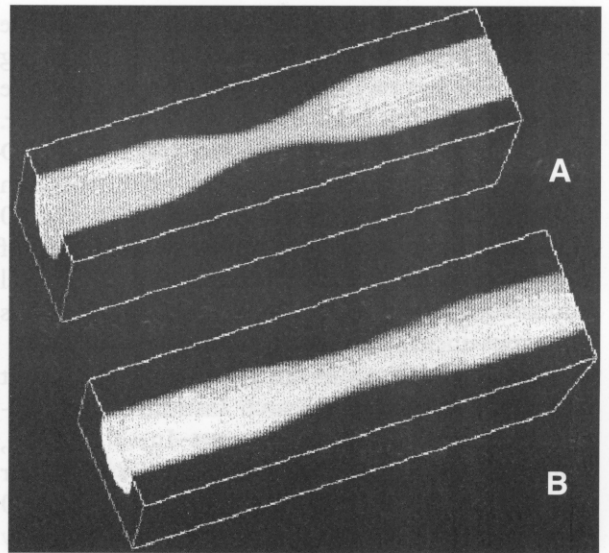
Three dimensional (3D) power Doppler angiograms of the wall-less agar lumen show an 80% area reduction stenosis (A) and a 50% area reduction stenosis (B). Pulsatile flow with a peak flow rate of 15 ml/sec was used to generate these two 3D angiograms.
